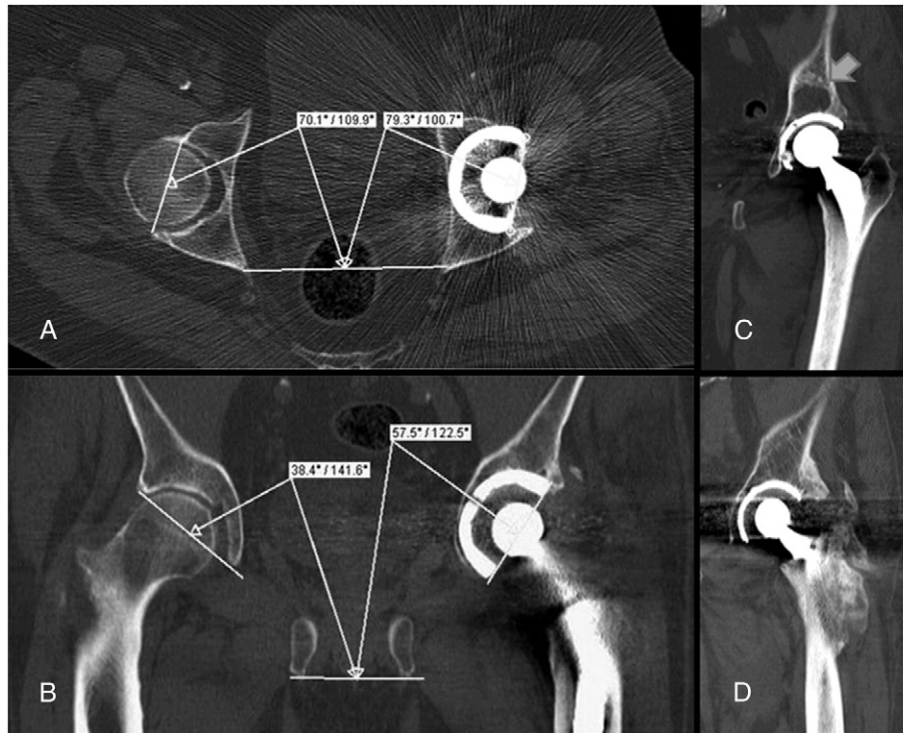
Computed tomographic scan assessment of cup position, based on the natural position of the contralateral acetabulum, in the transversal and frontal plane. (A) Cup placed in retroversion. (B) Cup placed with an excess of abduction. (C) Residual geode with ALMIS. (D) Heterotopic ossification with ALMIS.
